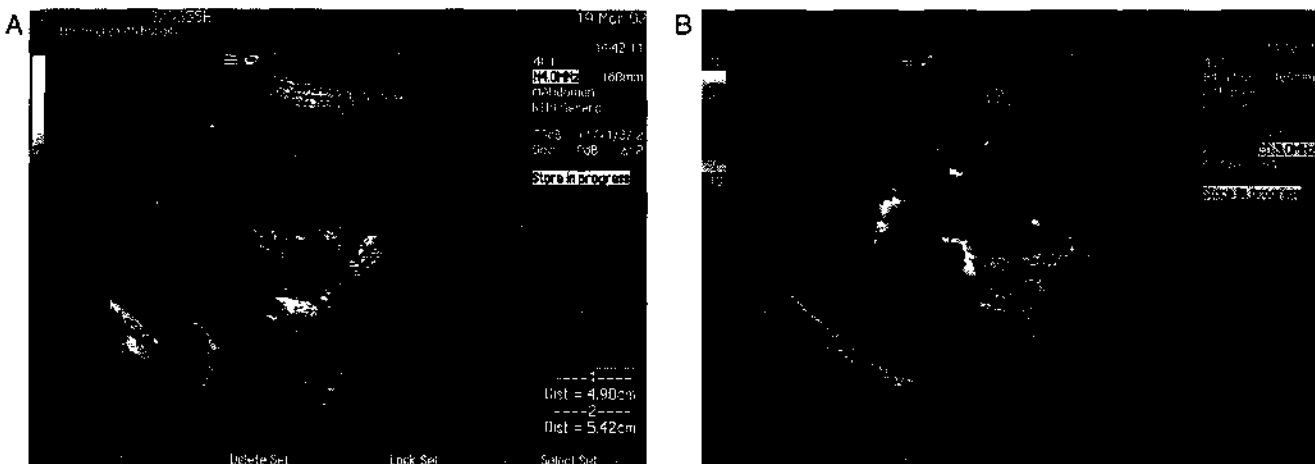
Hepatocellular carcinoma. This irregular 5-cm mass in segment V in a cirrhotic patient (A) is suggestive of an hepatocellular carcinoma, and this is reinforced by the demonstration of numerous tortuous blood vessels within it on color Doppler (B). (See Plate 5.)
